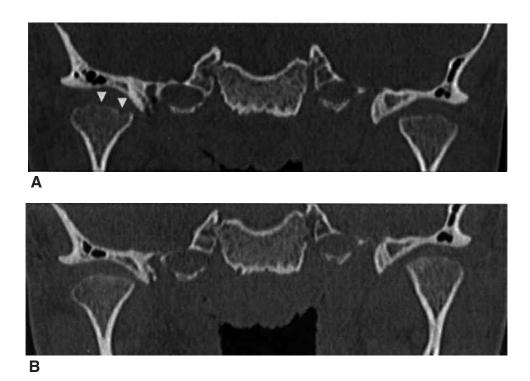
In a girl with ANA-positive polyarticular JIA diagnosed at age 14.75 years, comparison CT images show healing of condylar erosions after unilateral IAS injection of the TMJ. A. Image from the patient's first rheumatology clinic visit shows small erosions of the right condyle (arrowheads) with flattening of the condyles bilaterally. B. Followup image 9 months after she underwent IAS injection of the right TMJ shows healing of the small erosions on the right condyle. She also received weekly MTX during this period.
